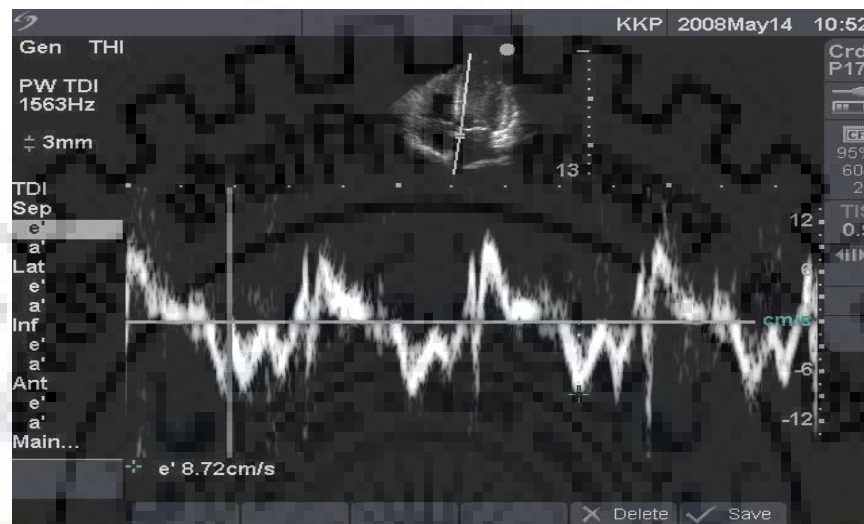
Tissue Doppler through Mitral annulus [3].
